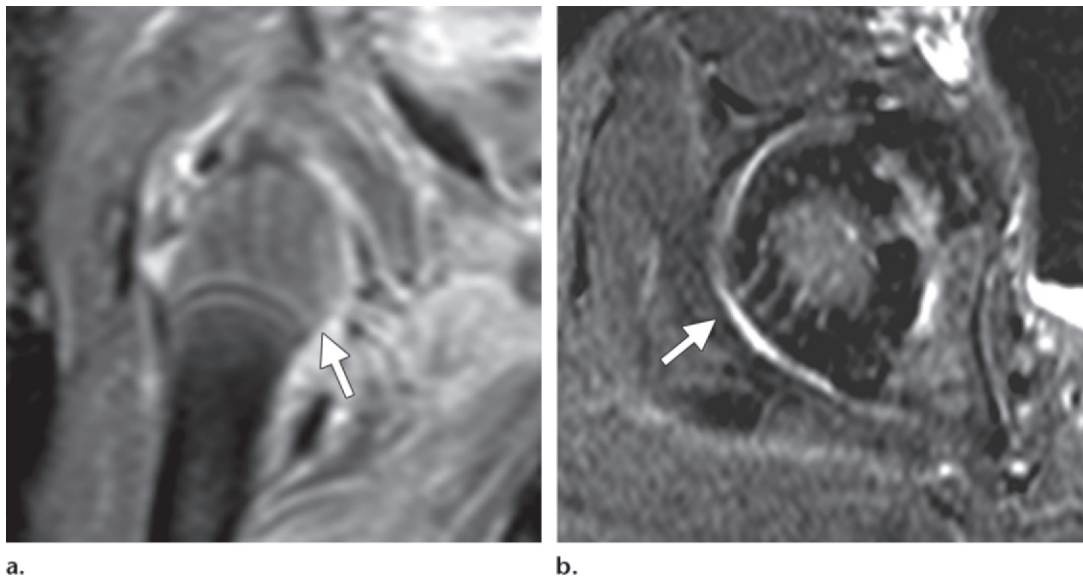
Normal enhancement of the epiphyseal vessels. (a) Coronal postcontrast T1-weighted MR image of the hip in a 2-month-old girl shows parallel vessels with no SOC (arrow). (b) Axial postcontrast MR subtraction image of the hip in a 6-month-old boy demonstrates a radial arrangement of vessels (arrow) and a central enhancing SOC.
